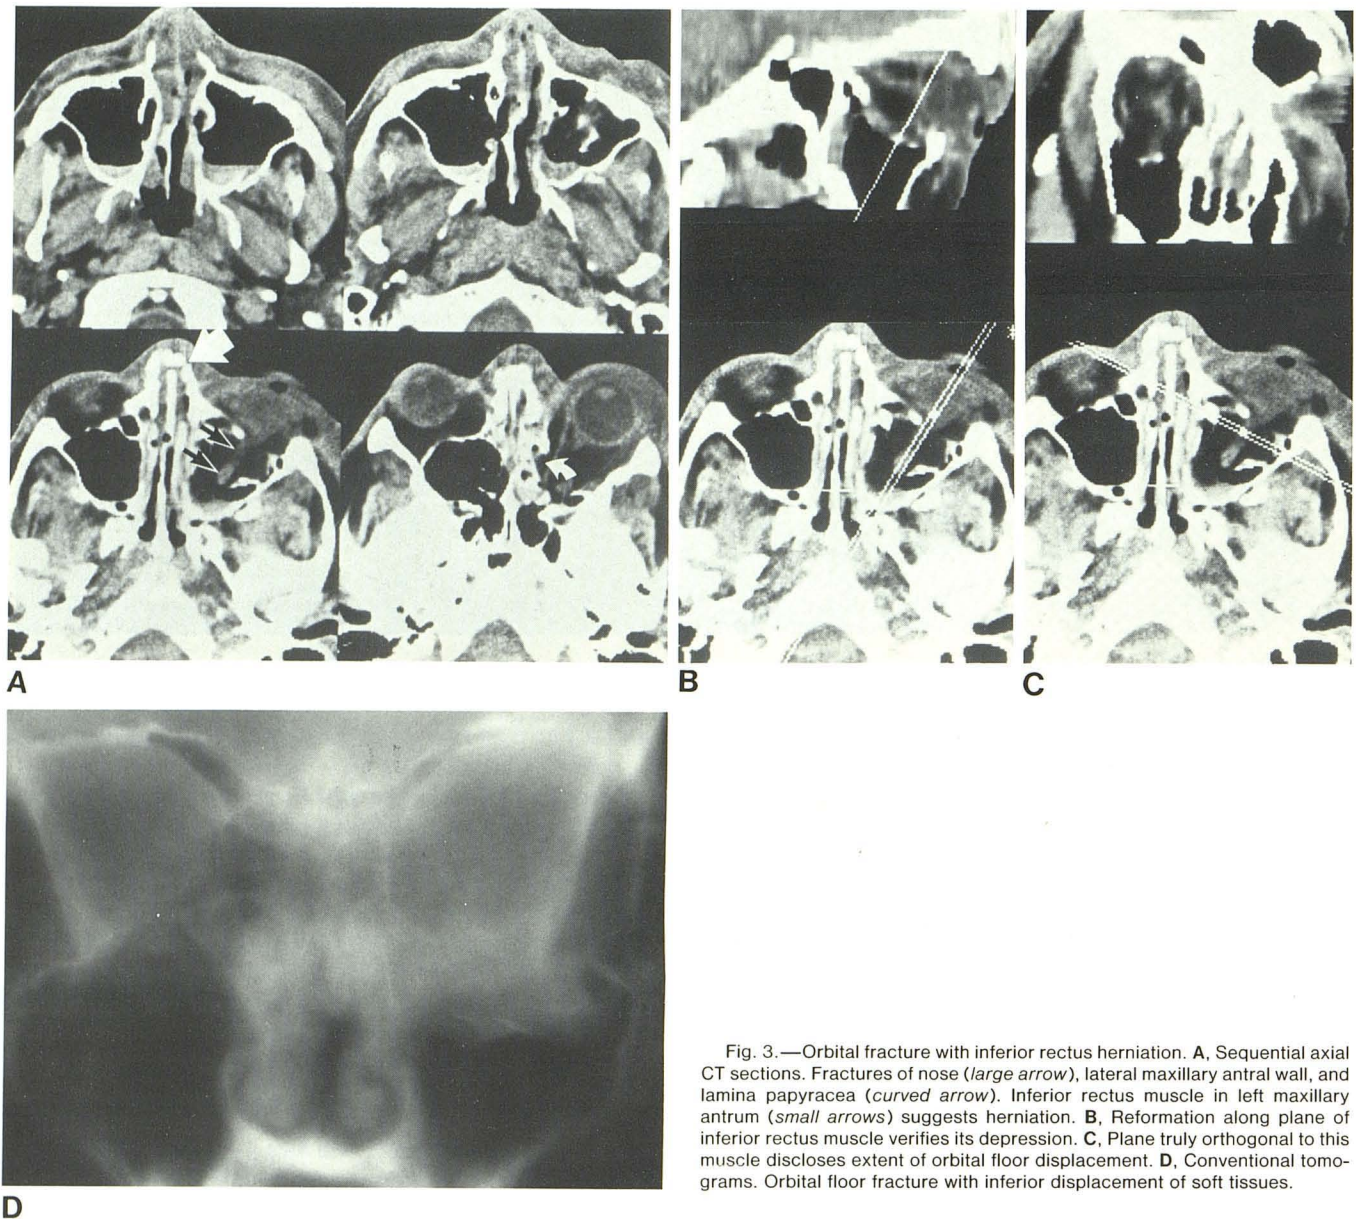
Orbital fracture with inferior rectus herniation. A, Sequential axial CT sections. Fractures of nose (*large arrow*), lateral maxillary antral wall, and lamina papyracea (*curved arrow*). Inferior rectus muscle in left maxillary antrum (*small arrows*) suggests herniation. B, Reformation along plane of inferior rectus muscle verifies its depression. C, Plane truly orthogonal to this muscle discloses extent of orbital floor displacement. D, Conventional tomograms. Orbital floor fracture with inferior displacement of soft tissues.
